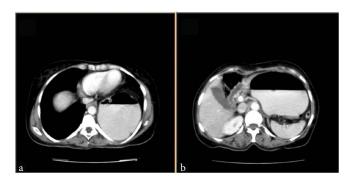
(a) CT scan of the thoracic region showing dilated and herniated part of the stomach with an air-fluid level. (b) CT scan of the abdominal part showing dilated stomach with air-fluid level with upward movement of the transverse colon and splenic flexure suggestive of organ axial rotation.
